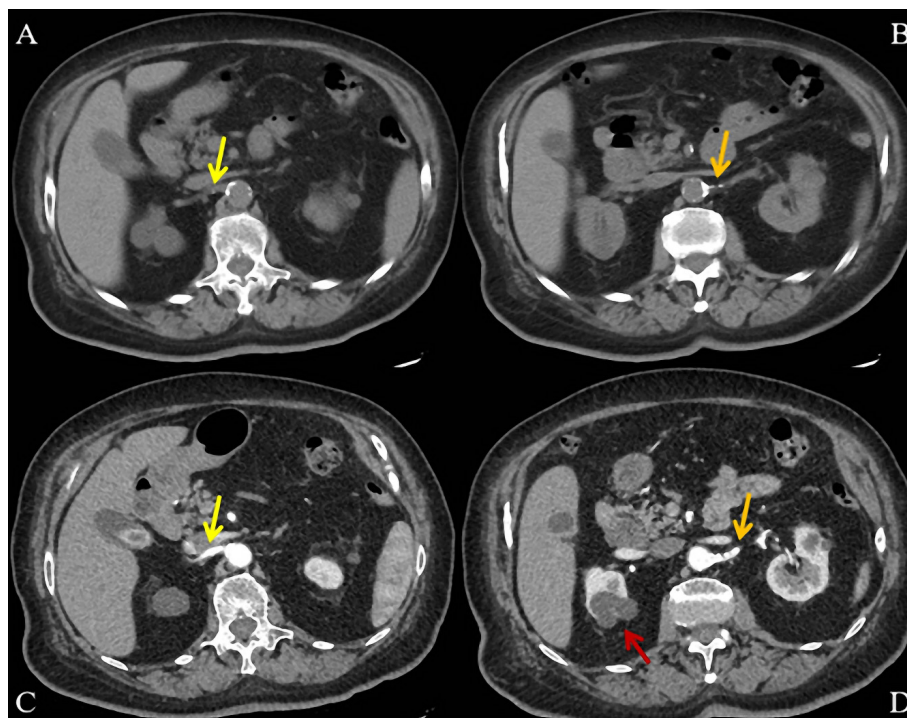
A-D. Abdomino-pelvic computed tomography. Calcifications of the abdominal aorta and of the right (A) and left (B) renal arteries at the origin on examination without i.v. contrast. Examination with i.v. contrast revealing ostial stenosis of the right (C) and left (D) renal arteries and a cortical renal cysts (D - red arrow).
